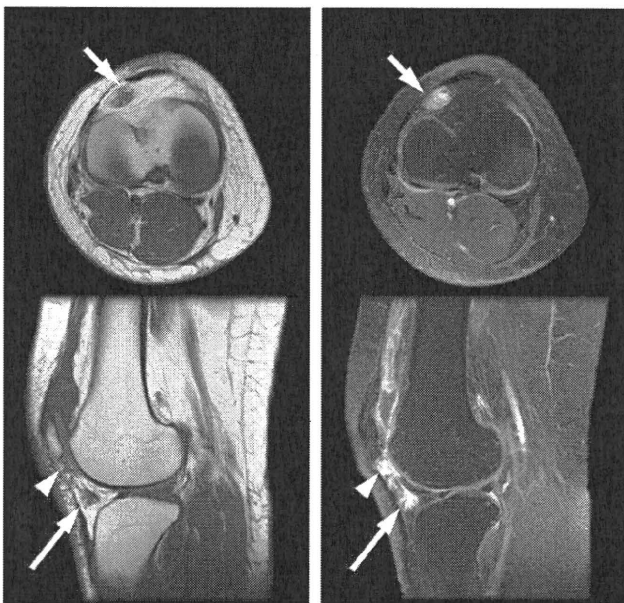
Gd-enhanced images (Case 1). Prior to Gd enhancement (left column), a heterogeneously low-intensity lesion is identified on both axial and sagittal images (indicated by arrows) within the lateral area of the infrapatellar fat pad. A portion of the lesion adjacent to the inferior pole of the patella is obscured (arrowhead). Gd enhancement with fat saturation clearly depicts the extent of the tumorous lesion as homogenous enhancement with low spots throughout the lesion (right column). [MRI: Signa 1.5 T (GE Medical Systems, Milwaukee, WI), T1^{pre}: TR/TE = 300/9.0, T1^{post}: TR/TE = 500/20, FOV = 160 × 160 mm, Slice thickness = 5 mm, 10 ml of Gadopentetate dimeglumine (Magnevist, Bayer) was intravenously administered].
